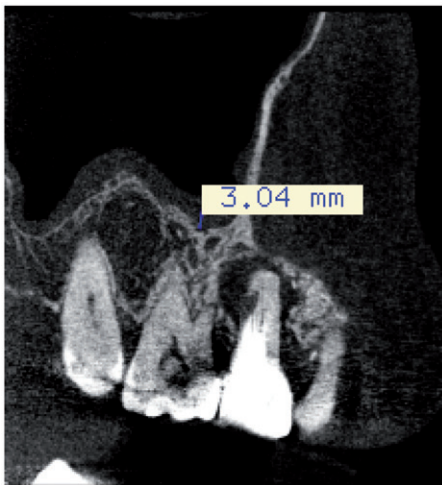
CBCT image showing a mucositis case.
